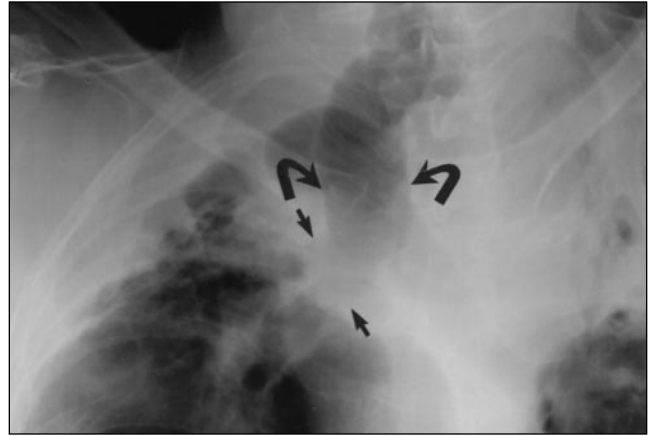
Traction tracheomegaly in 63-year-old man with prior history of tuberculosis. Posteroanterior chest radiograph shows severe upper lobe fibrosis resulting in displacement and dilatation of trachea (*curved arrows*) and main bronchi (*straight arrows*).
